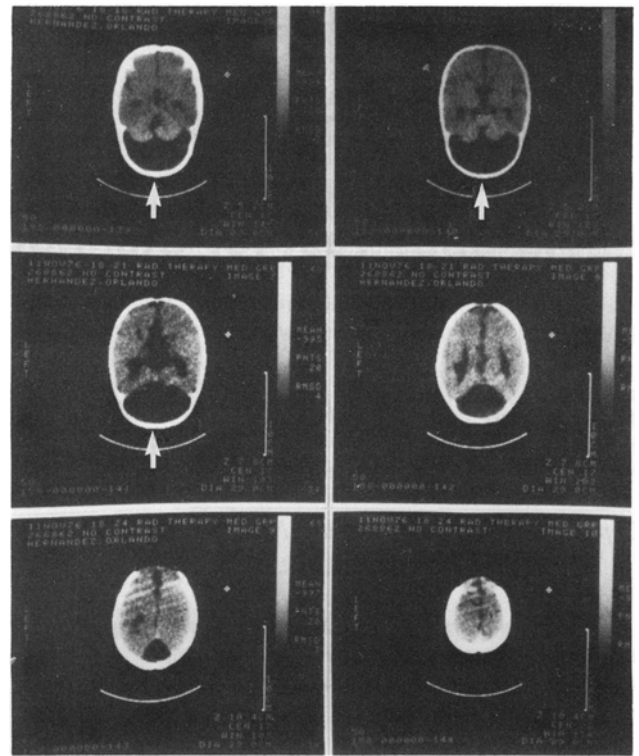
CT scan with arrows pointing to area of Dandy-Walker cyst.
